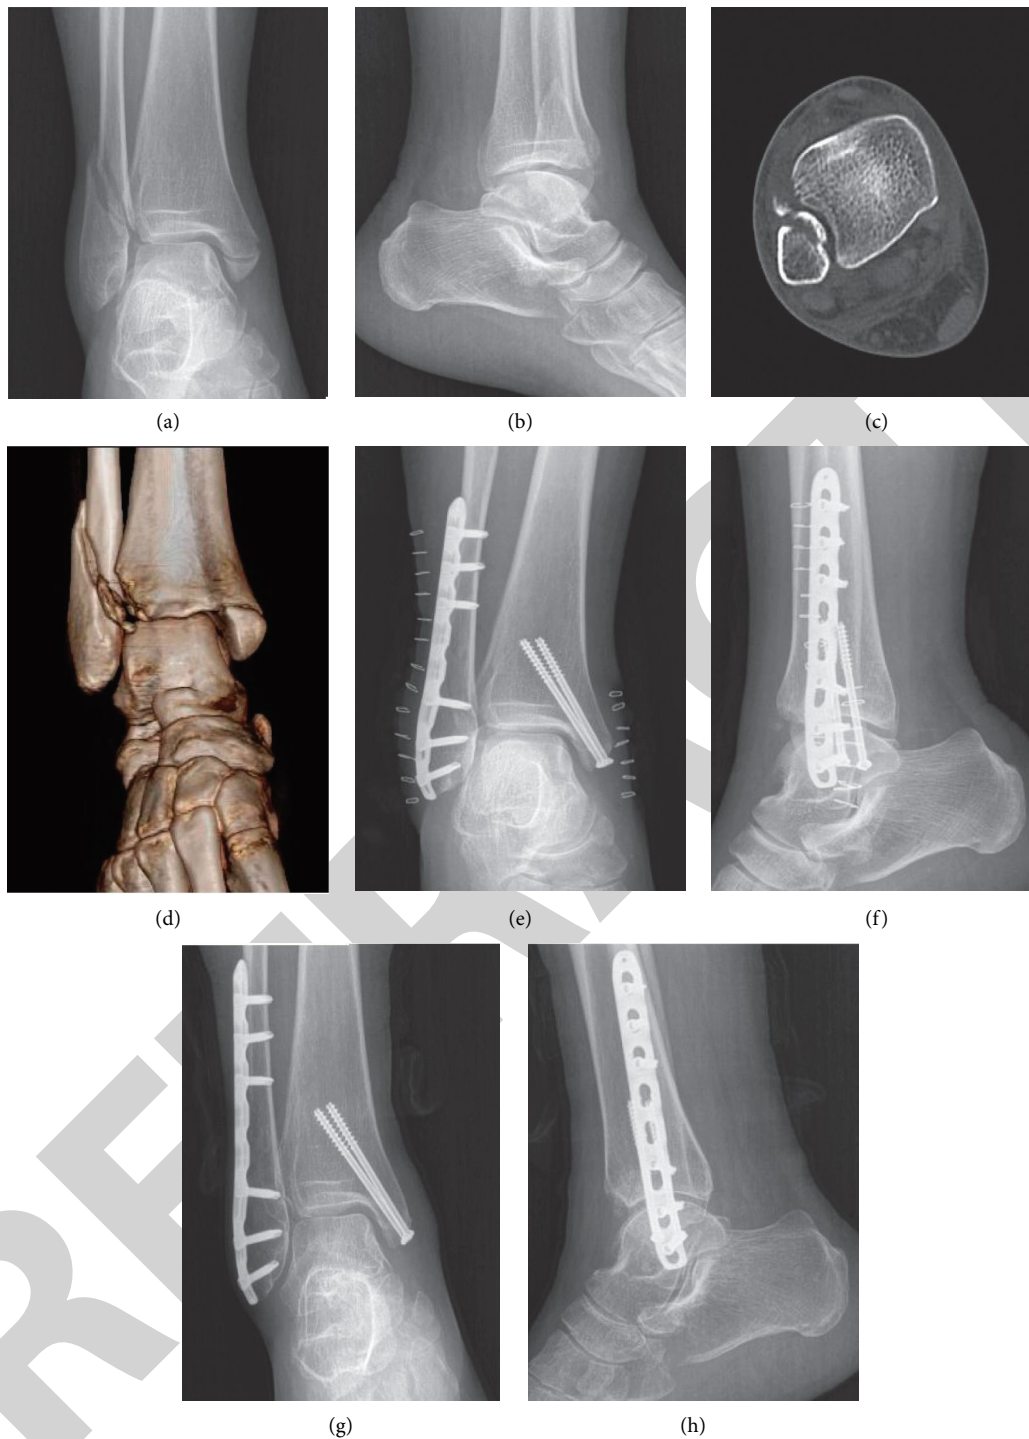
(a, b) A 47-year-old male patients with a right ankle fracture caused by trauma. (c, d) CT scan shows that the fracture involves medial-lateral and lateral malleolus. The fracture belongs to the supination-external rotation-type (GradeIII). (e, f) The supine position and lateral approach were used, a plate was used to fix the lateral malleolus, and two lag screws were used to fix the medial malleolus. (g, h) One year after surgery, the X radiographs show that the fractures were healed well, and the ankle function recovered excellently.
